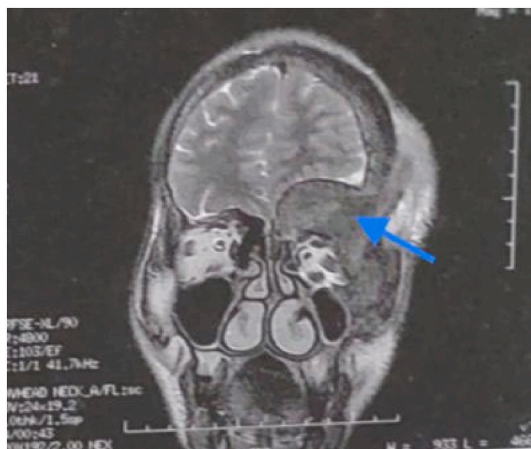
Brain MRI shows large hypodense frontotemporal lesion.
